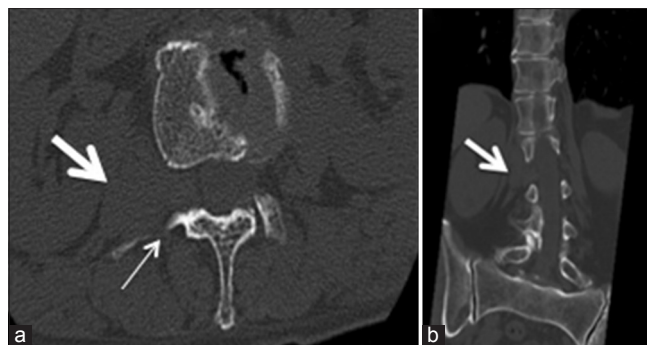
(a) A transverse computed tomography (CT) scan at the level of L2/3 showing a left-sided dumbbell-shaped mass (thick arrow). The posterior wall of the right intervertebral foramen was slightly eroded (thin arrow). (b) A coronal CT scan demonstrating the mildly enlarged right intervertebral foramen and dumbbell-shaped mass (thick arrow)
